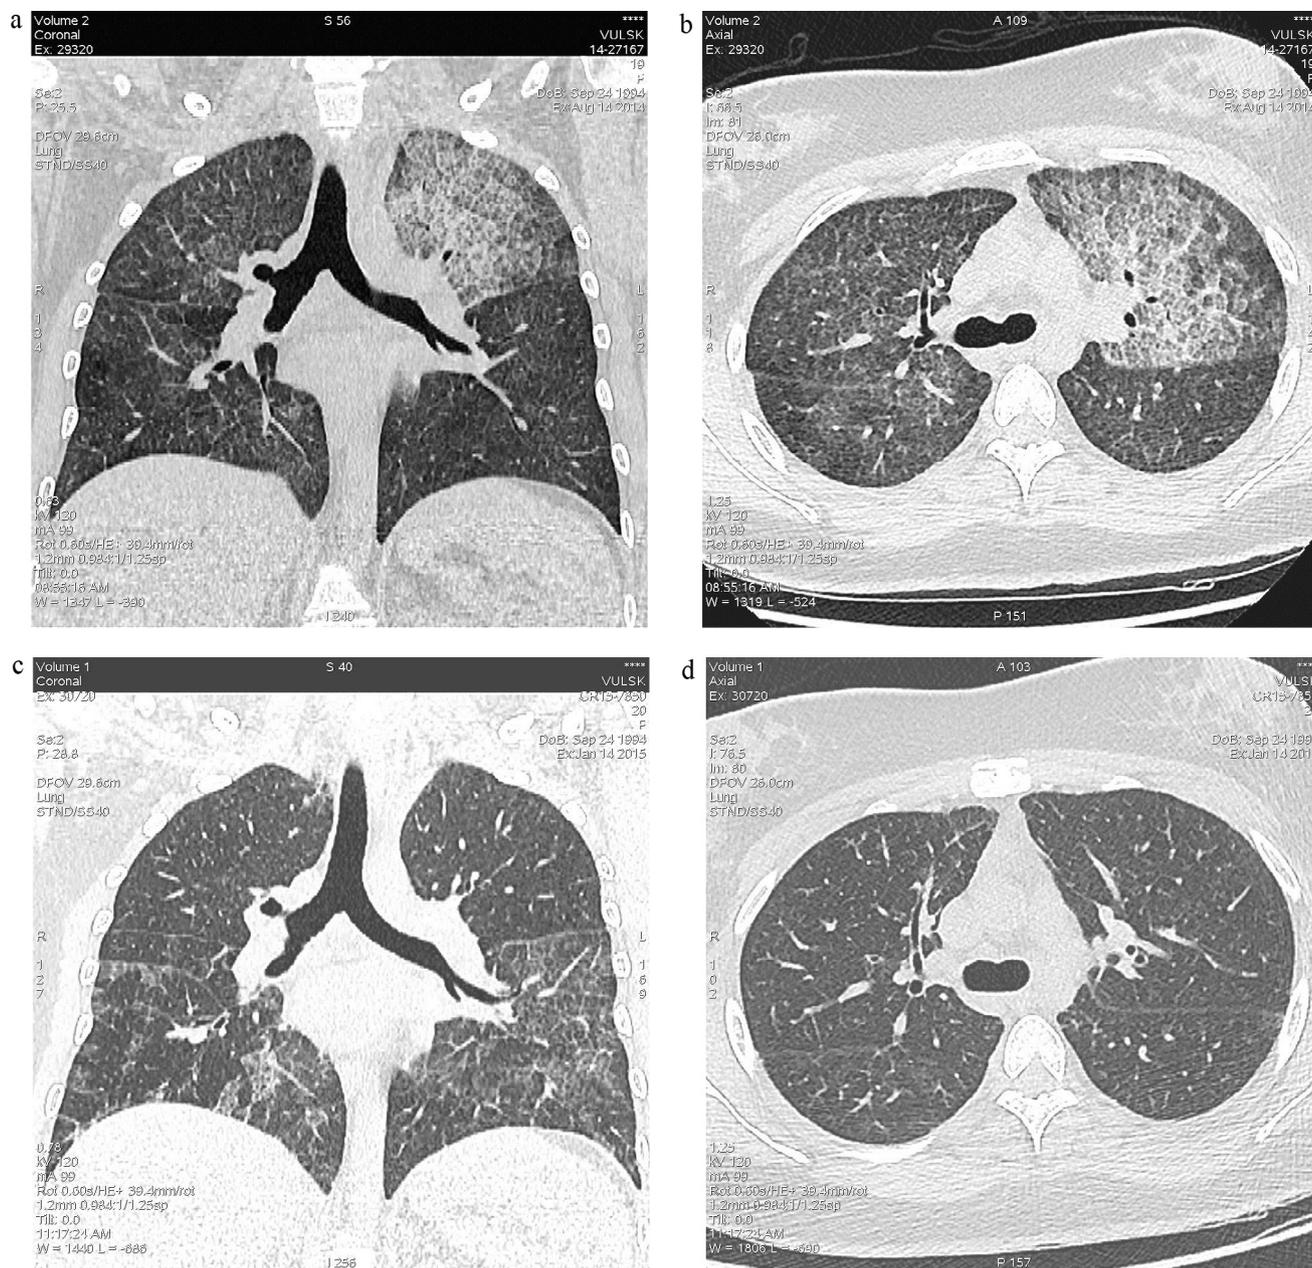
(a and b) Post-BAL CT scan (axial and coronal reformatted image, lung window) demonstrates the near-complete resolution of ground-glass opacity in the right lung and the lower lobe of the left lung as well as the residual crazy-paving pattern in the upper lobe of the left lung. After medical treatment, a CT scan (lung window) obtained at the identical level reveals residual septal lines and a nearly-complete resolution of ground-glass opacity, including the upper left lobe (c and d).
